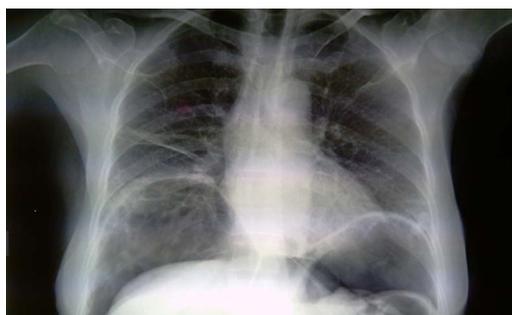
Supine chest x-ray showing air under the diaphragm.
